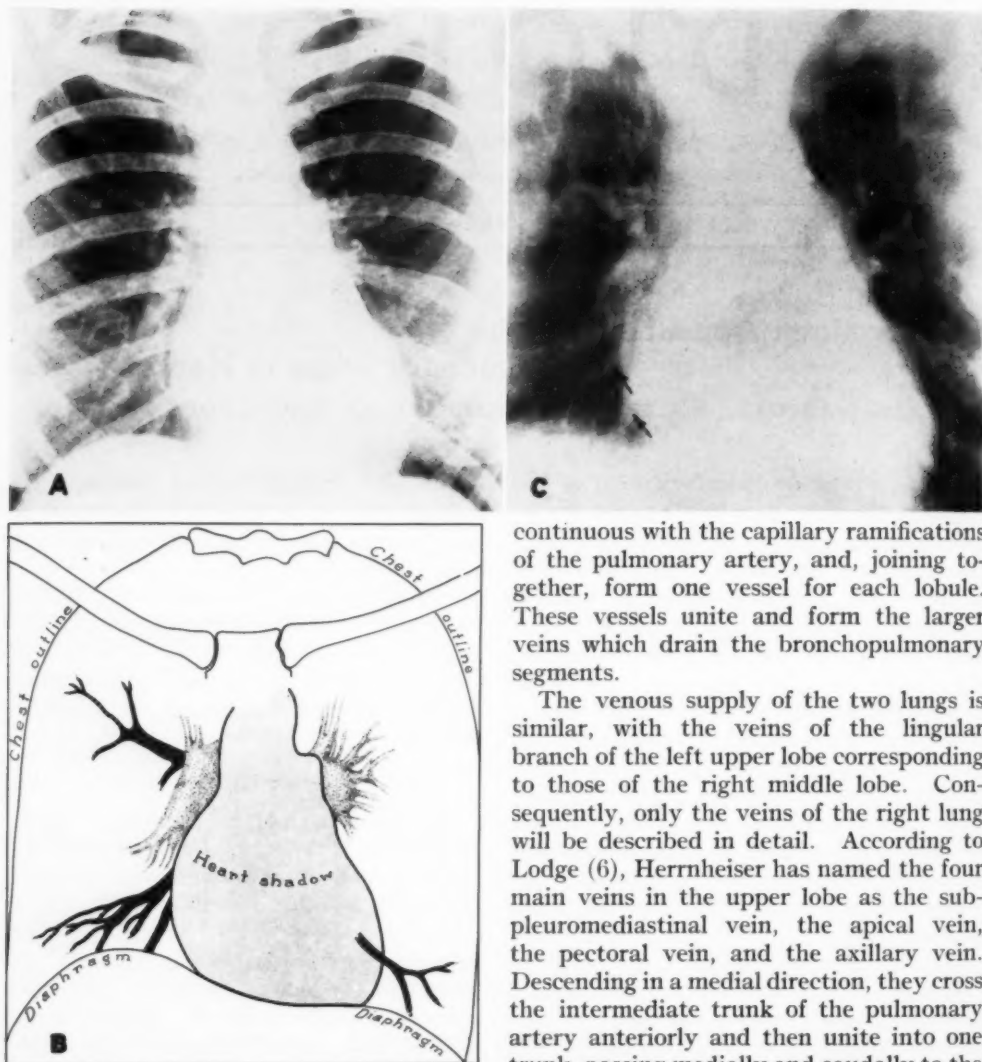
A. Roentgenogram of a postero-anterior projection of a normal chest. The veins draining the upper and lower lobes on the right side and a single trunk from the left lower lobe are demonstrated.
